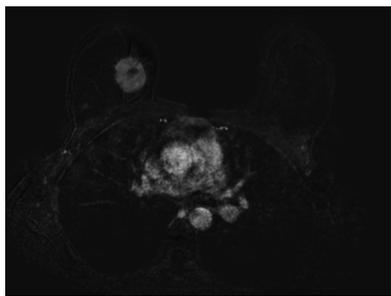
Subtracted THRIVE contrast enhanced MR image showing a Luminal B HER2- breast cancer of the right breast in a 54-year-old woman with mild BPE evaluated in the contralateral breast.
